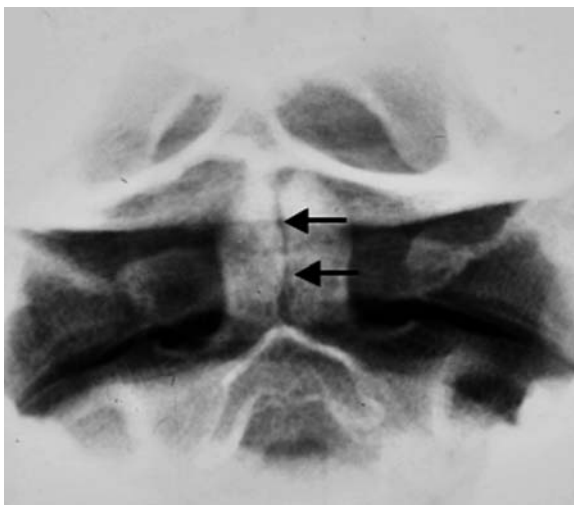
Vertical cleft of the dens axis. Open-mouth odontoid view radiograph. Non-ossified physiologic vertical cleft within the dens (*arrows*)
